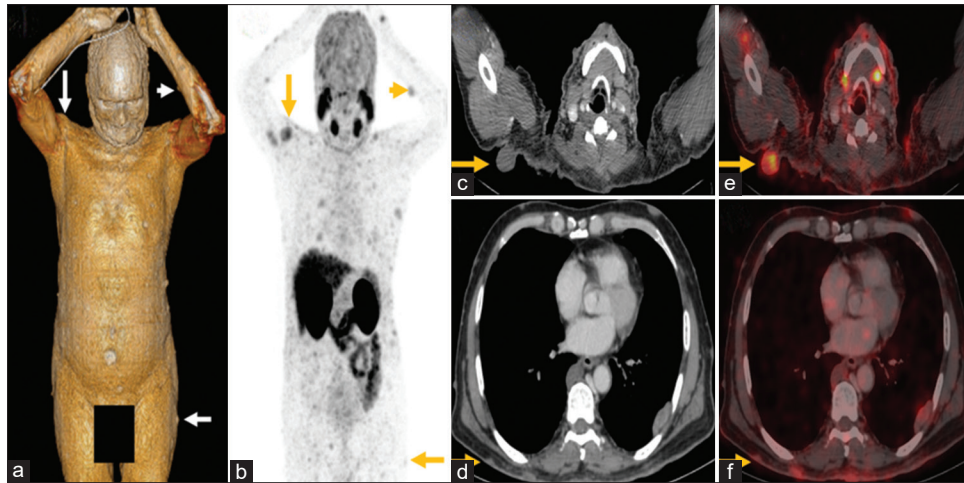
This is a 65-year-old male, known case of neurofibromatosis (NF type II), presented with urinary hesitancy, frequency for 1 month with one acute episode of urinary retention. Serum PSA- 14.98ng/ml. 68Ga PSMA PET/CT scan was advised and done. 3D volumetric reconstruction was performed on the CT scan for finer visualization of the cutaneous neurofibromas (a). MIP (Maximum Intensity Projection) image shows low grade PSMA expression in multiple neurofibromas (b; arrows); CT and fused images of cervical and thoracic regions in axial plane (c-f, respectively; arrows) show multiple PSMA expressing cutaneous, subcutaneous, thoracic and abdominal neurofibromas (SUVmax 7.39)
